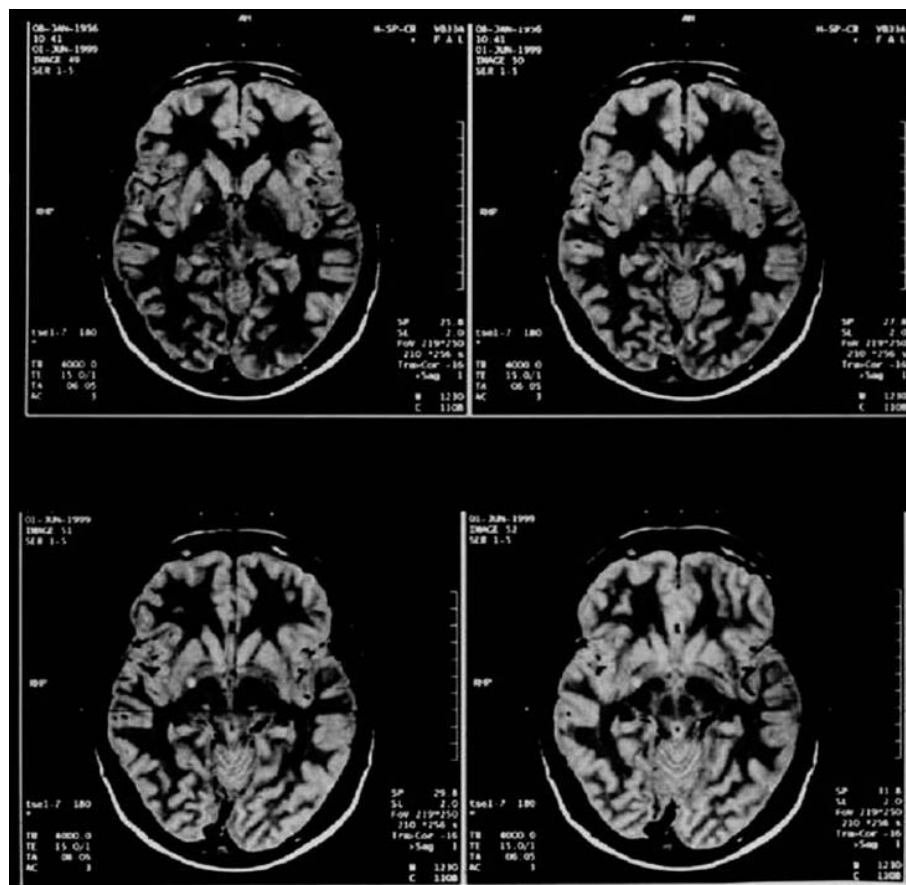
Stereotatic MRI using a proton density sequence performed 1 year after surgery: four contiguous axial 2 mm thick scans showing subdivisions of the pallidii, and a right-sided pallidotomy confined to the posterior and ventral internal pallidum.
